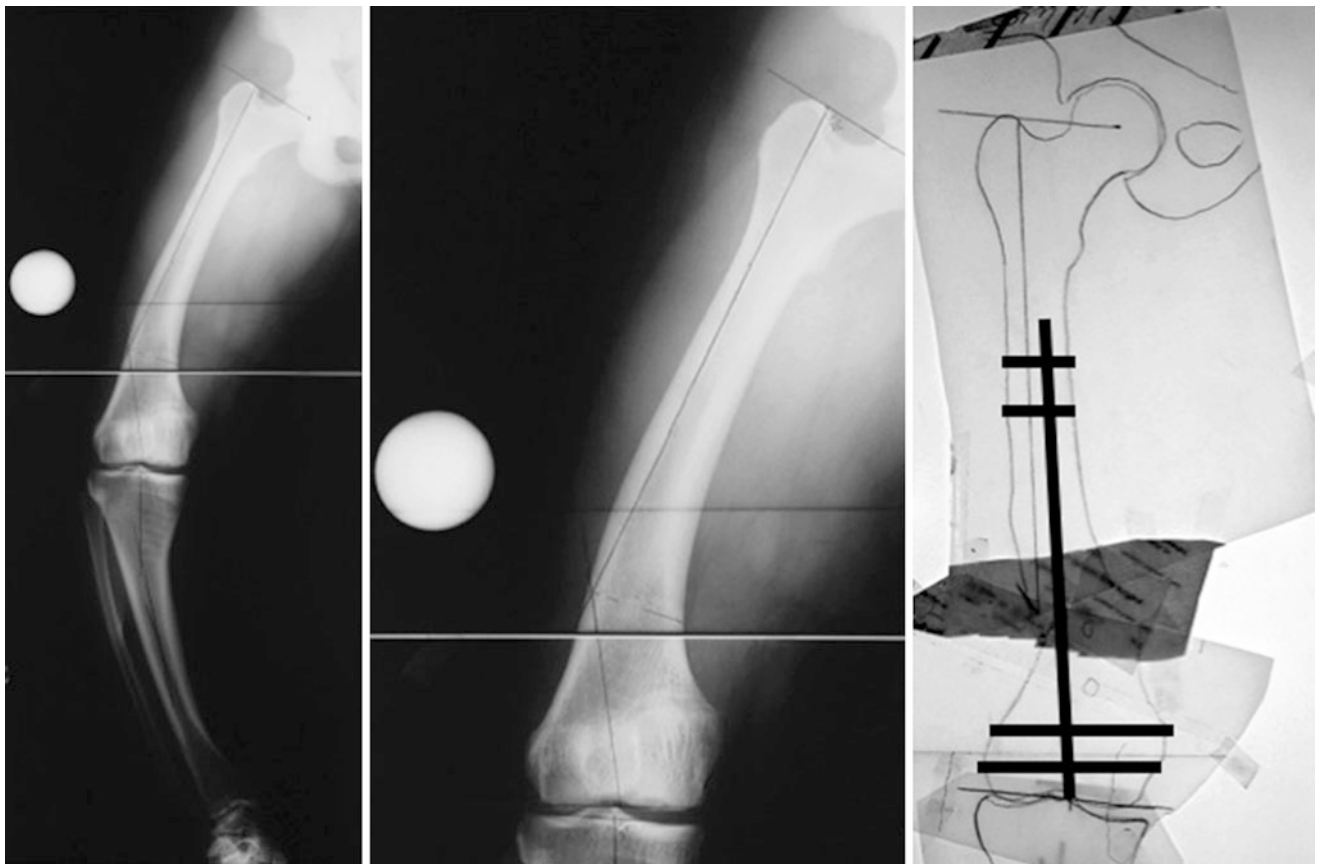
Preoperative X-rays and paper tracing planning for the right femur
